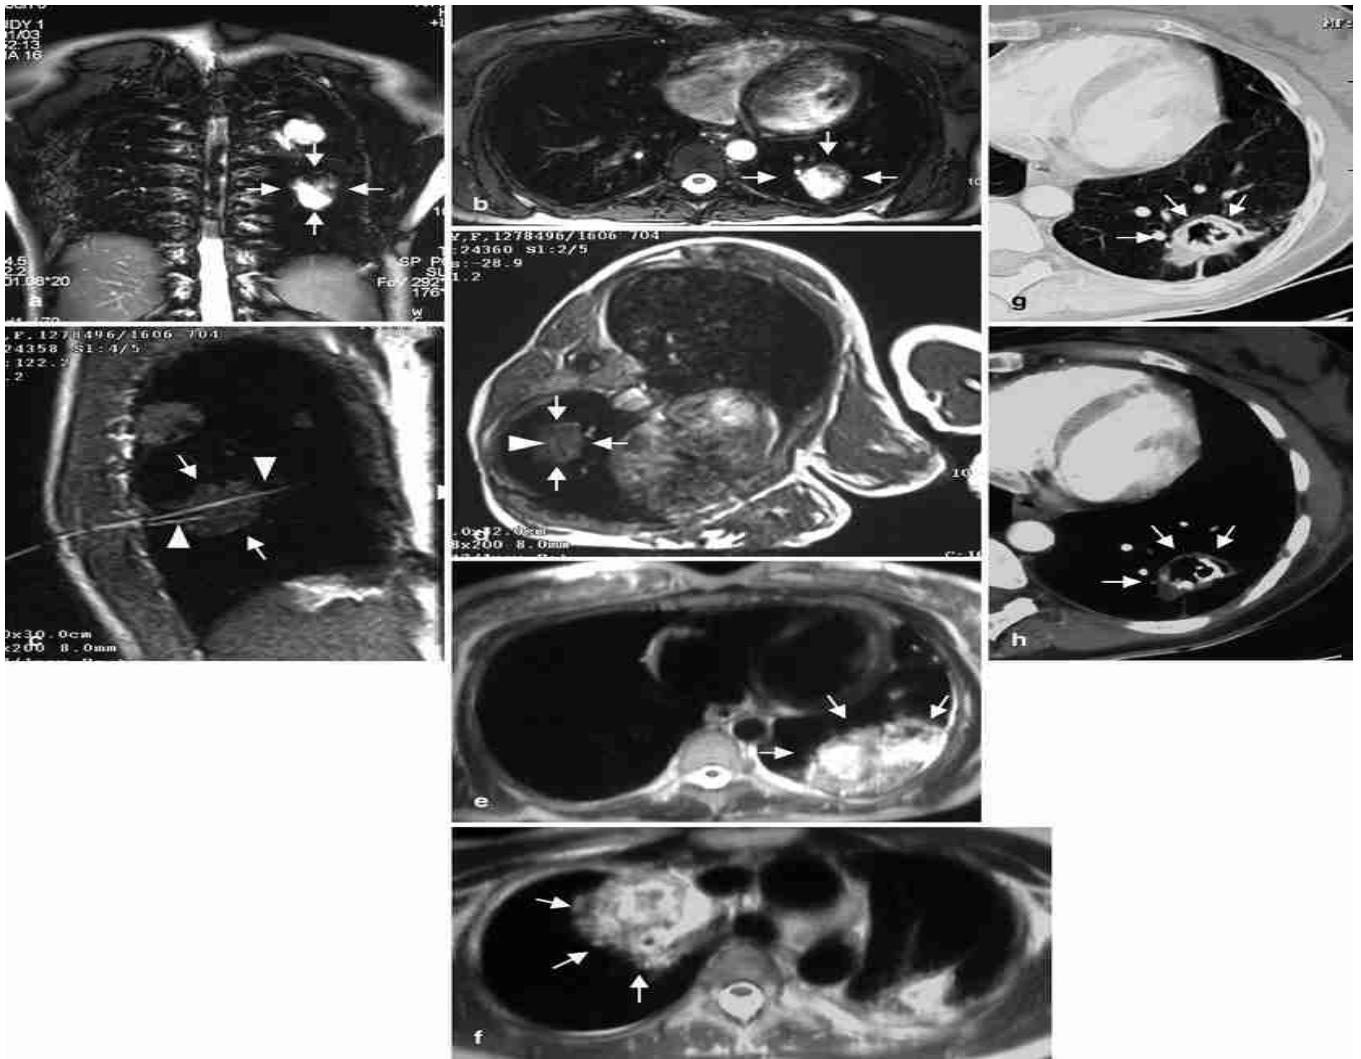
a, b T2-weighted images (TR/TE=4.5/2.2) obtained 2 weeks before laser treatment show the pulmonary chondroma in the left lung (*arrows*). c, d Unenhanced T1-weighted images (TR/TE=140/12) immediately before starting the LITT treatment show the pulmonary chondroma (*arrows*) and the positioned laser fibers (*arrow head*). e T2-weighted images (TR/TE=1,000/57) obtained 24 h after laser treatment show the induced coagulation area (*arrows*) with some reactive perilesional tissue charring. f Unenhanced T2-weighted images (TR/TE=1,000/57) show the induced coagulation area (*arrows*) of the laser-treated pulmonary chondroma in the right lung 24 h after laser treatment. g, h CT images show a complete ablation of the chondroma 6 months after laser treatment (*arrows*)
